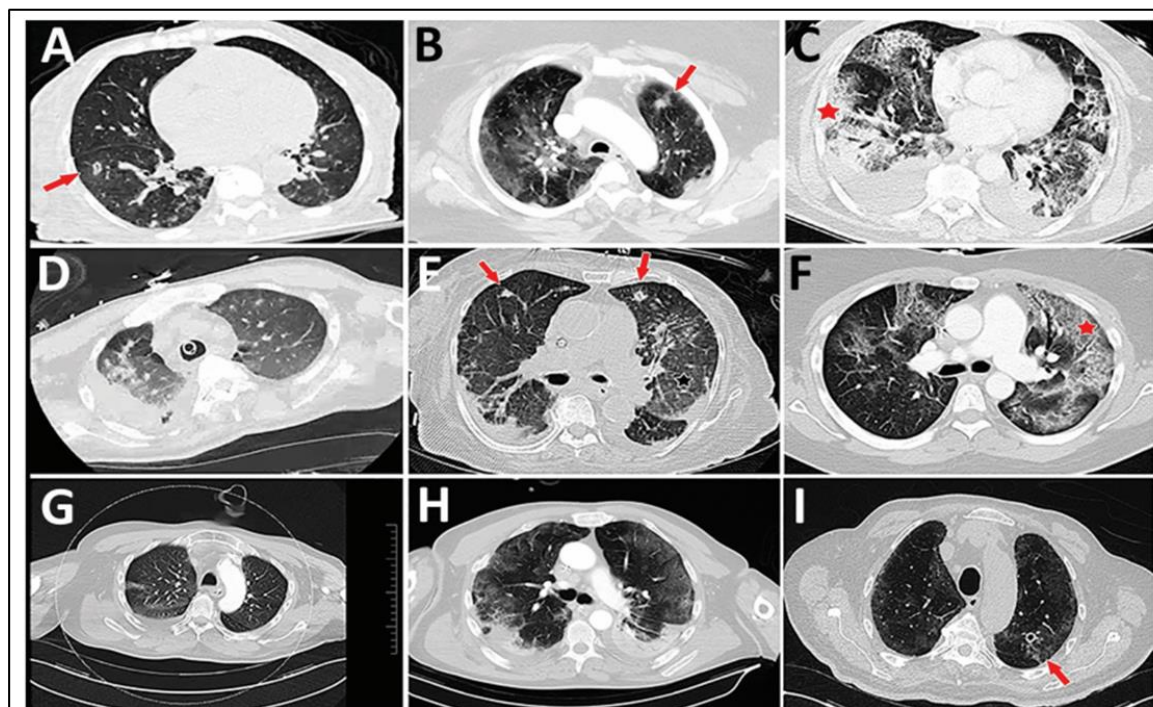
Representative computed tomography (CT) scans for 9 patients with aspergillosis complicating severe viral pneumonia in patients with coronavirus disease. Scans were obtained at or around diagnosis of coronavirus disease–associated pulmonary aspergillosis in this series of patients, described in the Table (<https://wwwnc.cdc.gov/EID/article/27/1/20-2896-T1.htm>). Corresponding case-patients are indicated with lettered superscripts in the radiology column of Table 1. Examples of nodules and cavitating nodules are indicated by red arrows, and prominent airway thickening and bronchiectasis in ground glass opacities are indicated by red stars.
